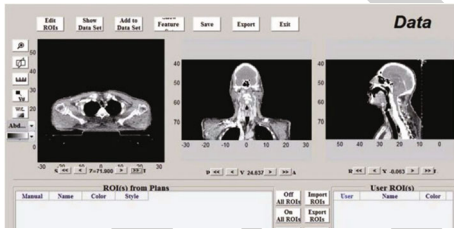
CT image display in Ibex.
